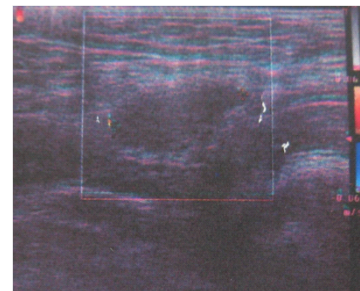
Ultrasonographic scan shows left inguinal cryptorchidism.
